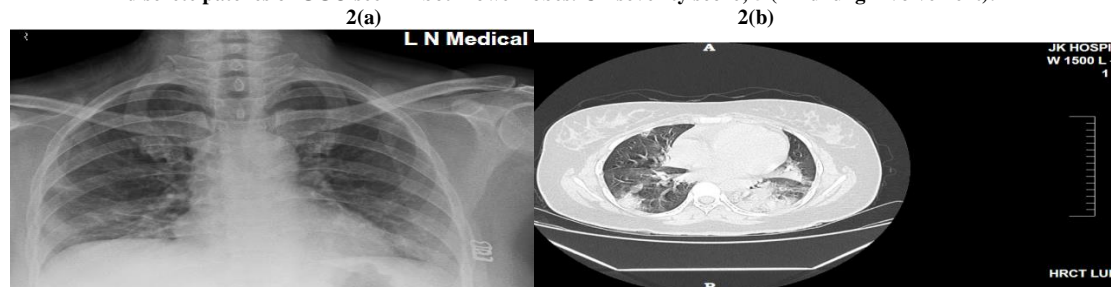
(a)-Chest radiograph of 18yrs old RTPCR positive patient showing GGO in bilateral lower zone and middle zone. 2(b)- HRCT of same patient showing multiple discrete and confluent patches of GGO seen in both lower lobes, left lingular lobe and right middle lobe. CT severity score; 10 (Mild lung involvement).
